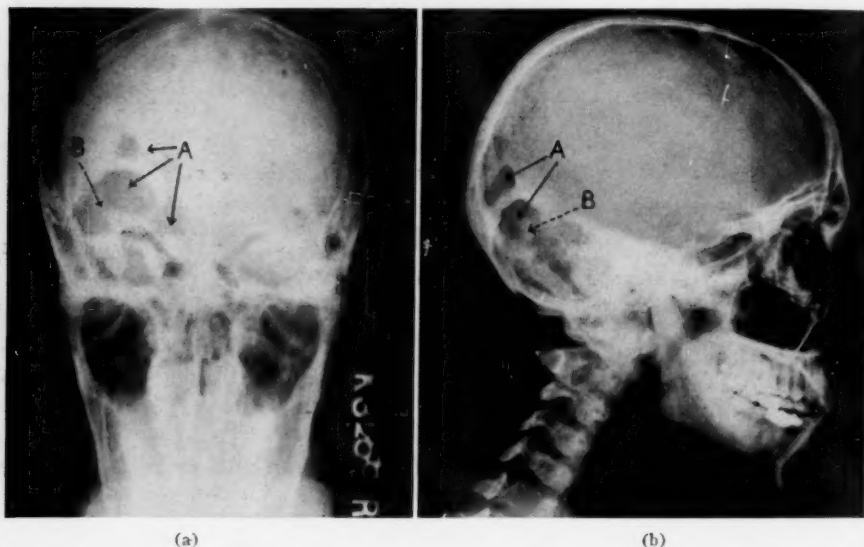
(a).—Case 3: Anteroposterior and (b) lateral roentgenograms. Areas of complete absence of outer table (A) with bridge of bone between. Island of bone (B).
